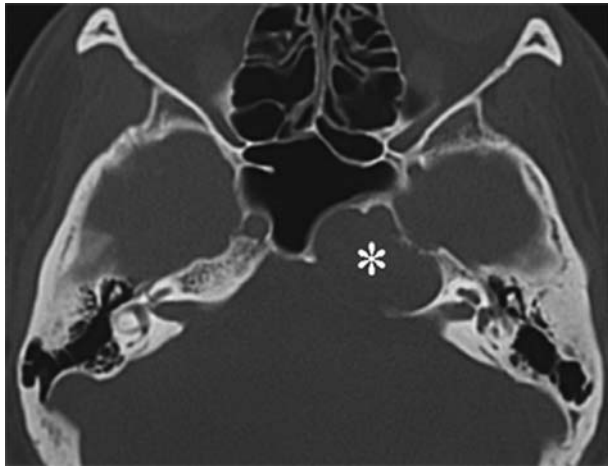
A CT scan showed that the left petrous lesion (*asterisk*) was separated from the posterior sphenoid sinuses by a thin layer of bone
